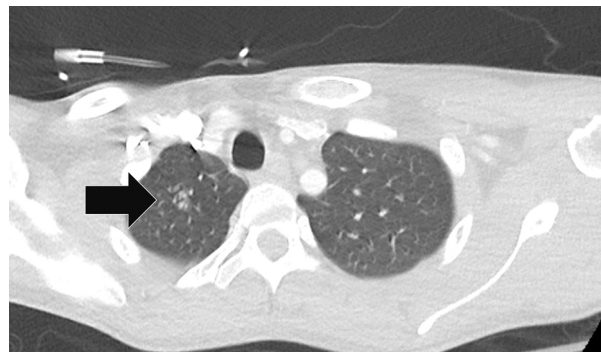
Noncontrast CT scan of the thorax demonstrating subtle right apical tree-in-bud opacity (black arrow).
